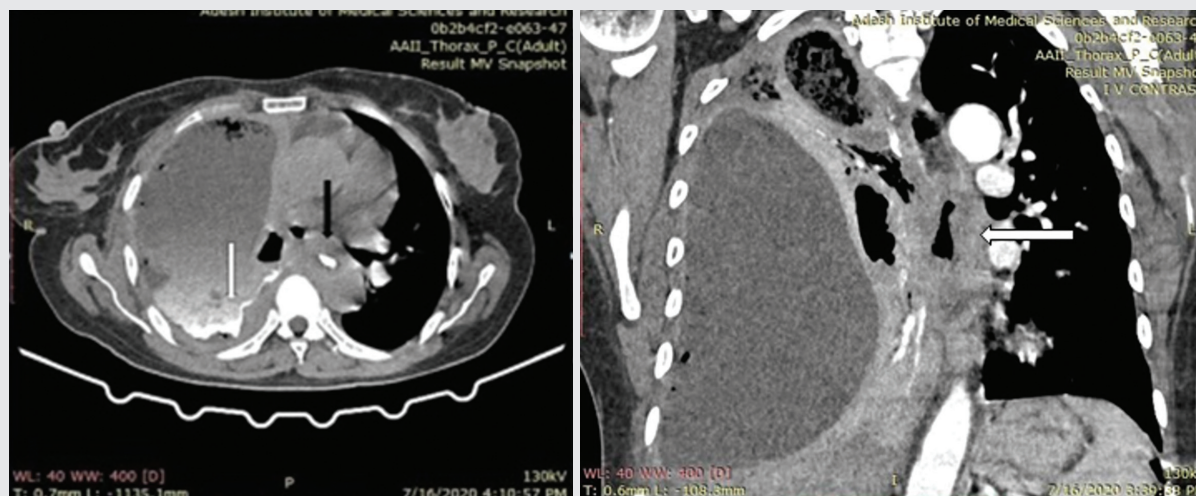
Axial and coronal CECT images show right sided hydro-pneumothorax. Oral contrast filled fistulous track seen from mid esophagus to right pleural cavity (shown as white arrow in axial CT). Circumferential eccentric wall thickening of esophagus is seen (shown as black arrow in axial CT and white arrow in coronal CT)
